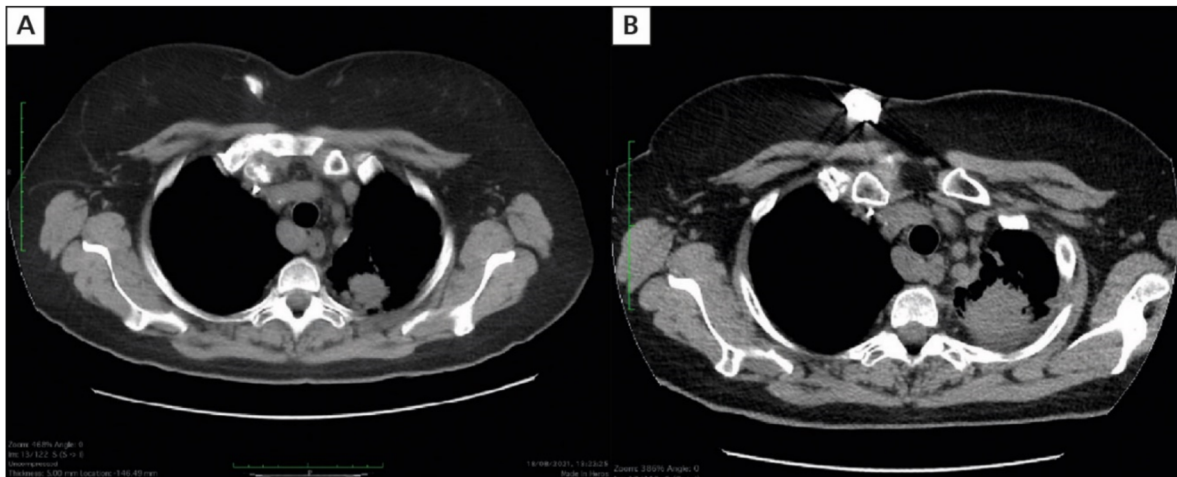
Progression of tumor in the apex of the left lung without G12C mutation in the *KRAS* gene; A. Computed tomography (CT) performed before sotorasib therapy; B. CT performed after two months of sotorasib therapy
